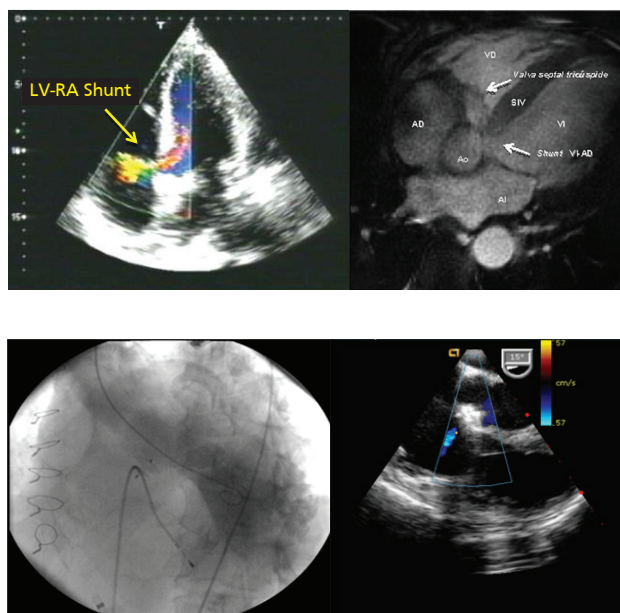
Gerbode defect. A. Left: Four-chamber view of transesophageal echocardiogram showing the shunt from the left ventricle (LV) to the right atrium (RA) (arrow). Right: Four-chamber view of cardiac magnetic resonance image in white blood sequences, showing the shunt from the LV to the RA (arrow). RV: Right ventricle, IVS: interventricular septum. Ao: Aorta. LA: left atrium. B. Left: Angiographic image showing the Amplatzer® device correctly positioned with absence of contrast passage from the LV to the RA. Right: Transesophageal echocardiography in parasternal long axis view showing absence of shunt and interference in aortic and tricuspid valve functioning.
